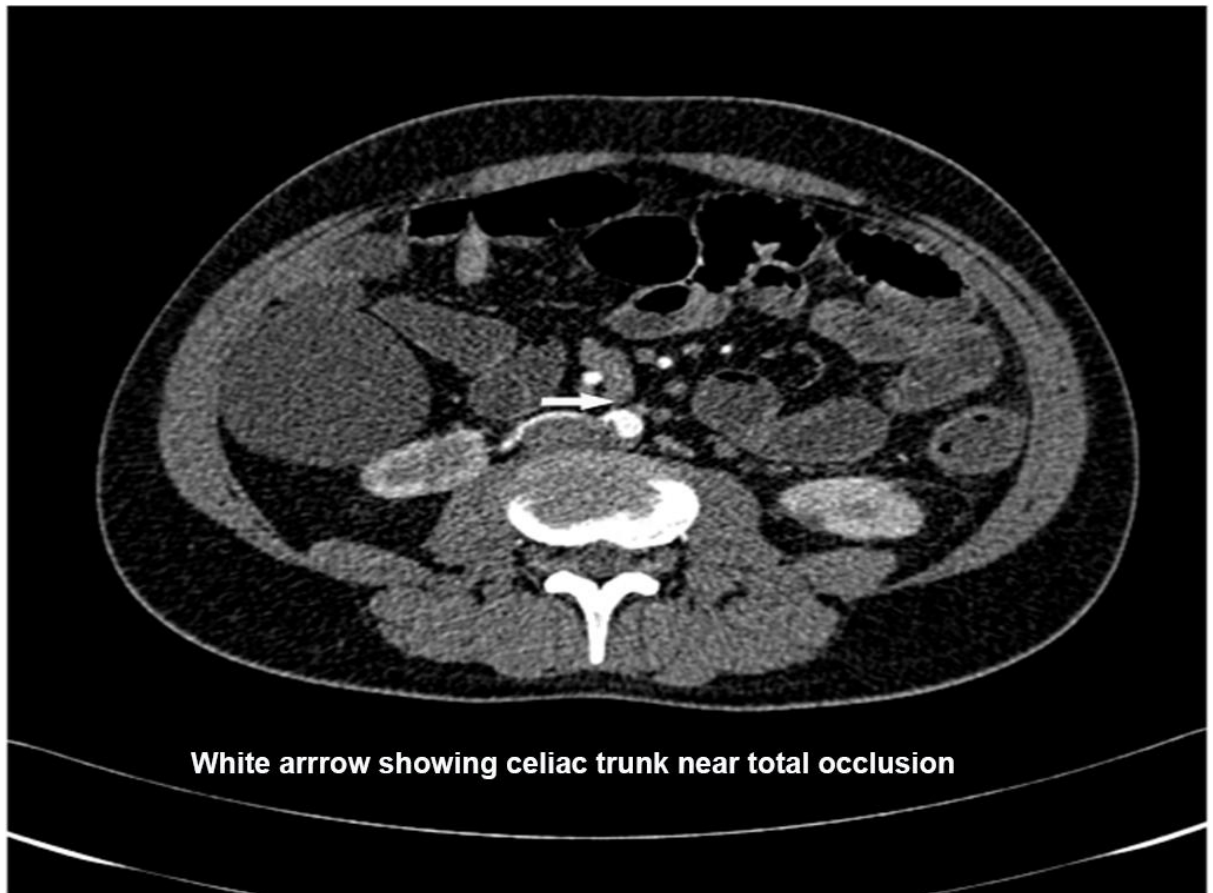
CT scan abdomen showing near total occlusion of the Celiac trunk.
